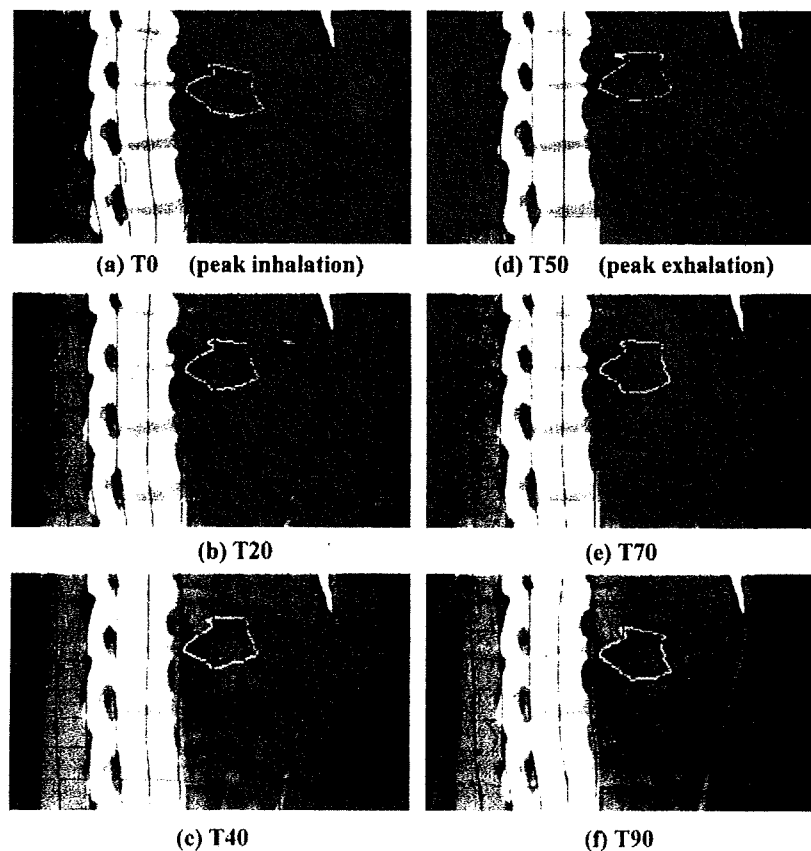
Four-dimensional sagittal CT images (patient no 5). (a) T0 (peak inhalation), (b) T20, (c) T40, (d) T50 (peak exhalation), (e) T70 and (f) T90. The yellow line and blue mesh grid show the GTV contours and deformed space from peak exhalation, respectively.
